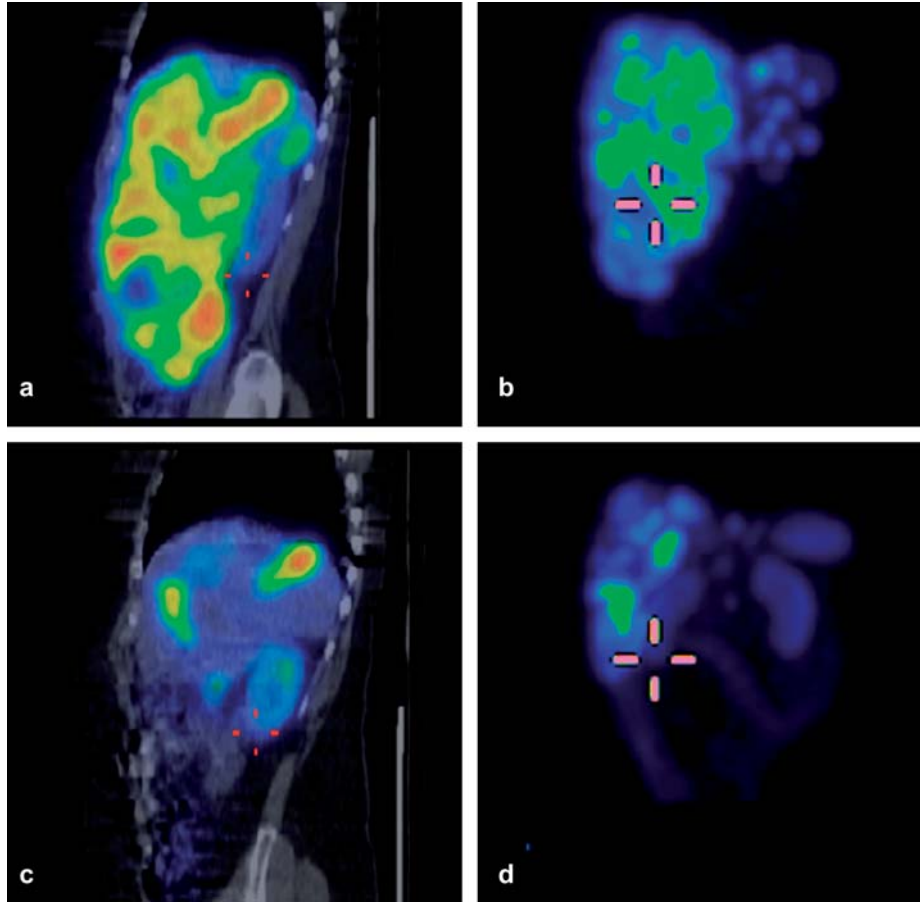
Example of change in tumor volume (liver metastases, hair cross on caudal pole of right kidney) during therapy in patient no. 8 (rectal carcinoid). SPECT/CT images 24 h after cycle 1 (a, b) and 6 (c, d); (a, c: fused sagittal views) b, d: maximum intensity projections.
